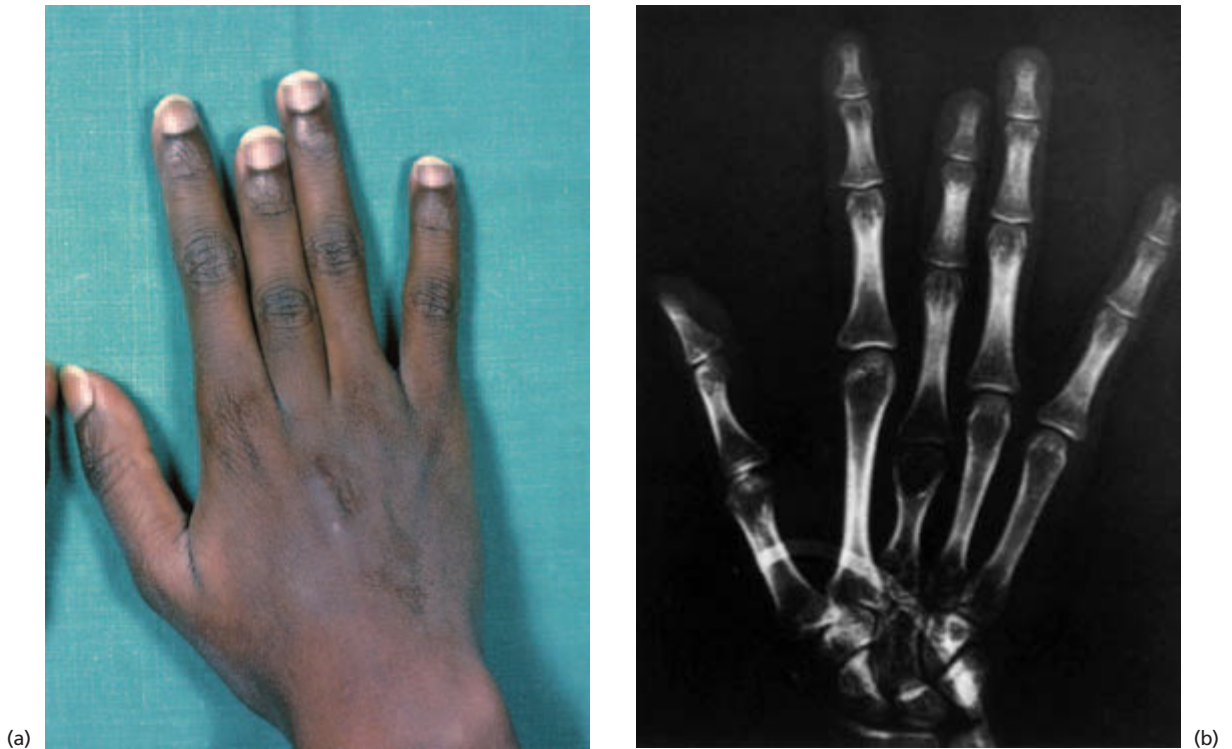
Long-term result of 'dactylitis' in sickle cell anaemia: (a) the hand of an 18-year-old Nigerian man; (b) X-ray of the hand. (Reproduced from Hoffbrand AV and Pettit JE. *Essential Haematology*, 3rd edn. Blackwell Scientific Publications, Oxford, 1993, by kind permission of Professor A. V. Hoffbrand.)
